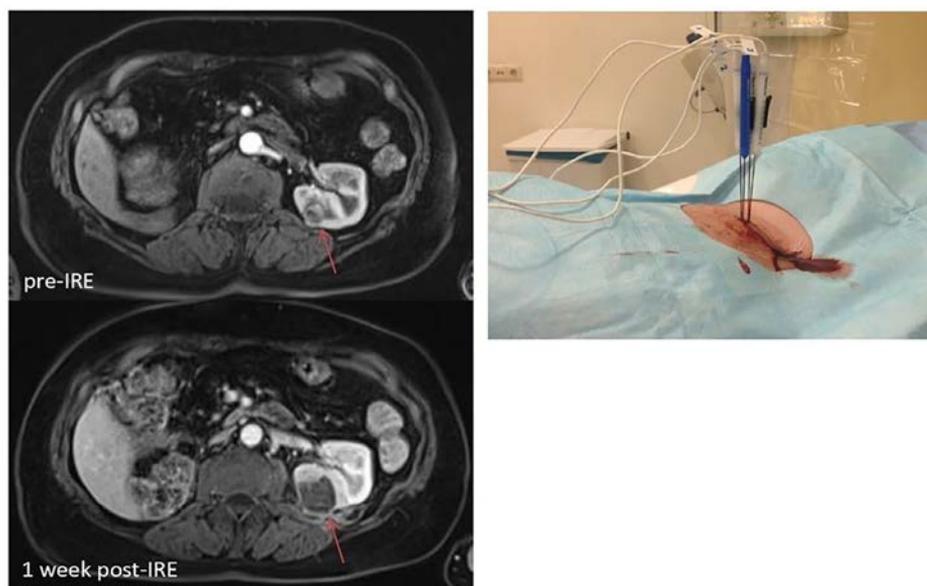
Left: MRI of pre-IRE tumor (red arrow), MRI and post-IRE ablation zone (red arrow). Right: Picture of IRE electrodes (blue and white) during the procedure. They percutaneously apply high voltage to the tumor. IRE = irreversible electroporation. (Color version of figure is available online.)
